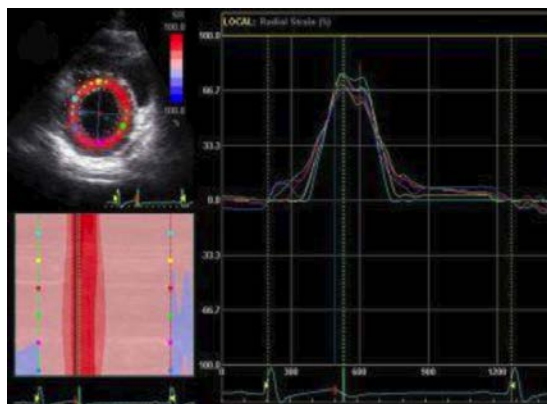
Two-dimensional radial strain recording in the apical 4-chamber view of the heart of a subject with normal left ventricular systolic function.
